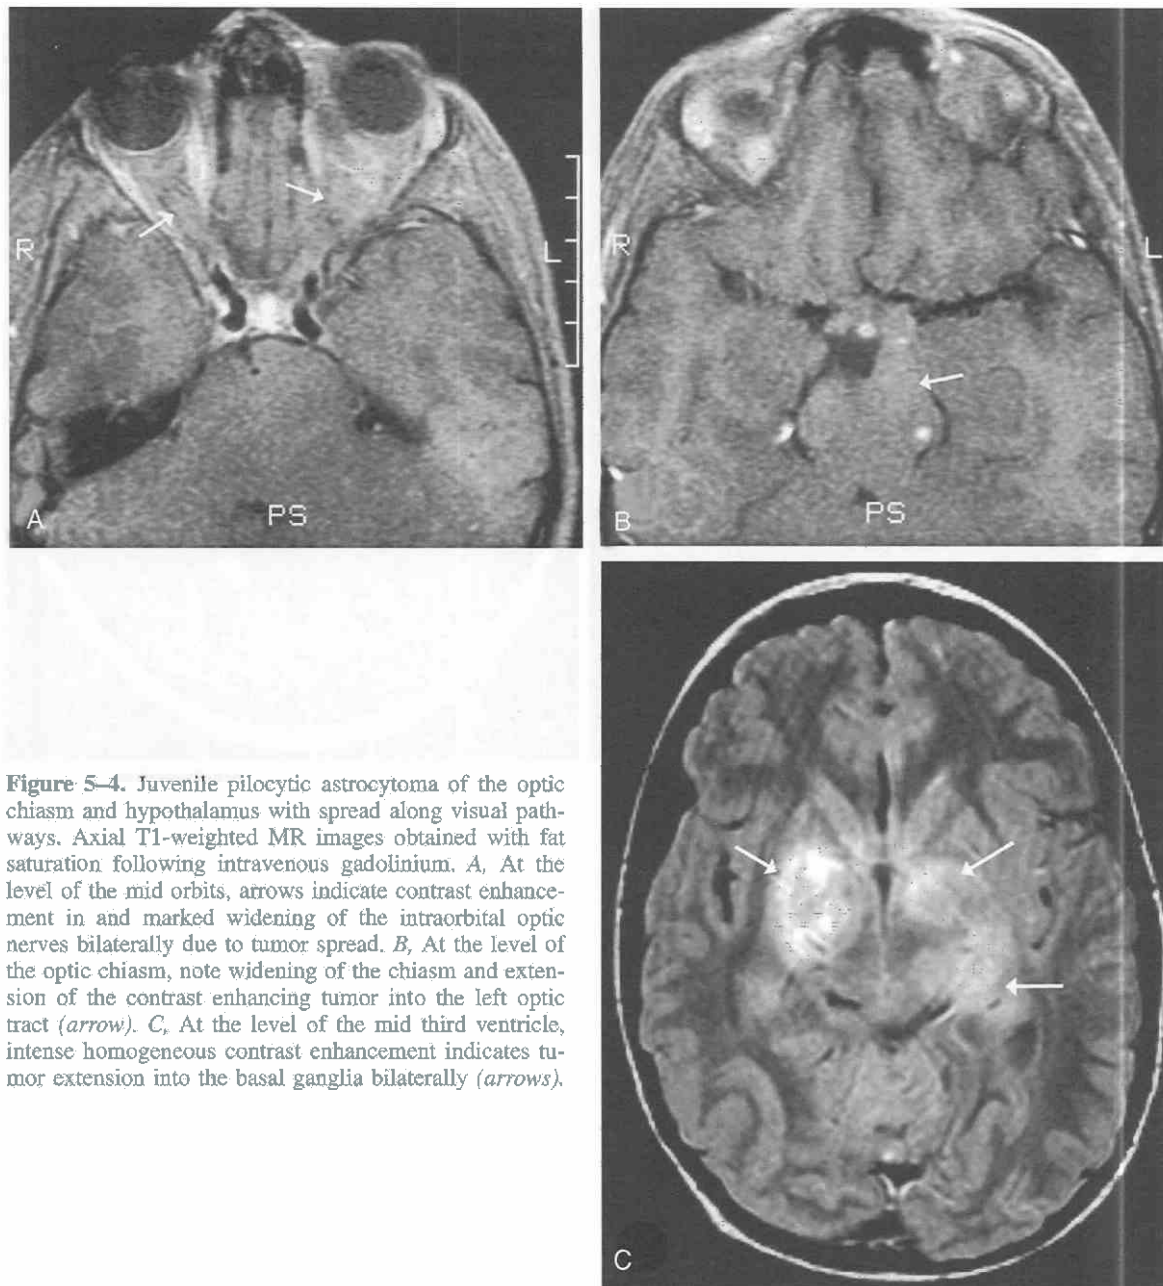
Juvenile pilocytic astrocytoma of the optic chiasm and hypothalamus with spread along visual pathways. Axial T1-weighted MR images obtained with fat saturation following intravenous gadolinium. *A*, At the level of the mid orbits, arrows indicate contrast enhancement in and marked widening of the intraorbital optic nerves bilaterally due to tumor spread. *B*, At the level of the optic chiasm, note widening of the chiasm and extension of the contrast enhancing tumor into the left optic tract (arrow). *C*, At the level of the mid third ventricle, intense homogeneous contrast enhancement indicates tumor extension into the basal ganglia bilaterally (arrows).
